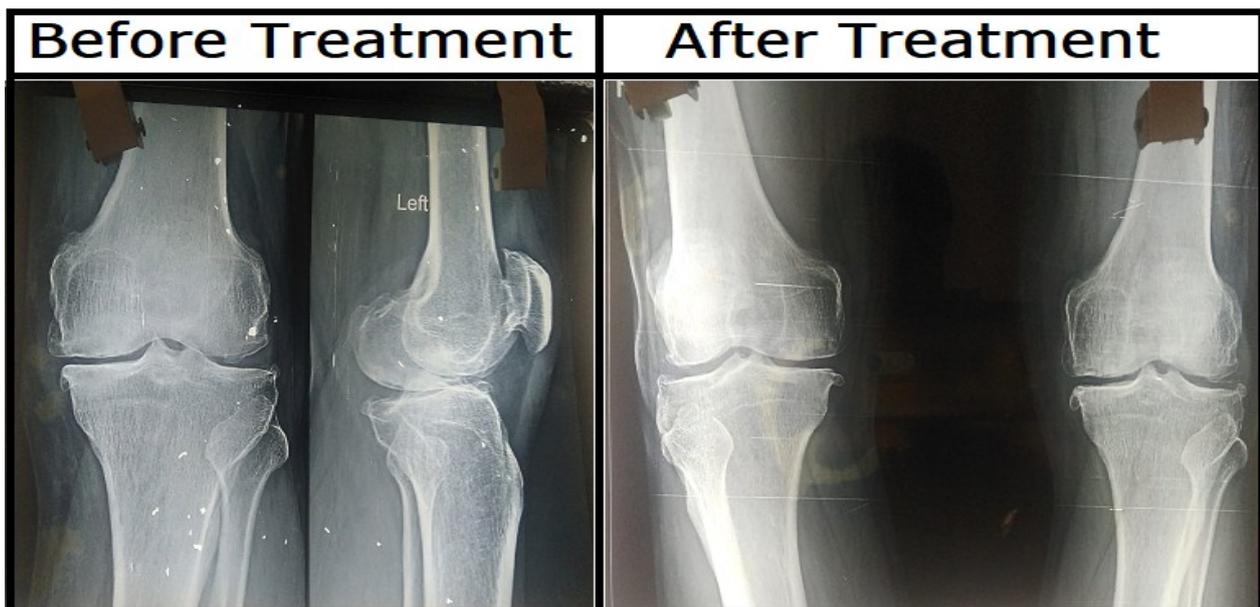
X-Ray of knee joint
